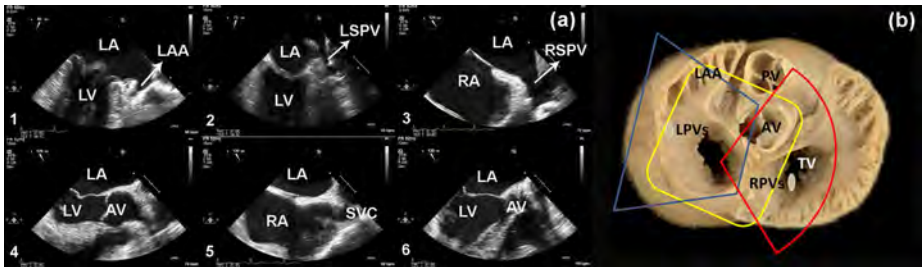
A: 2D transoesophageal echocardiography reference views of the 6-step image acquisition protocol. 1, the mitral commissural view; 2, the superior commissural view including the left upper pulmonary vein; 3, the modified bicaval view including the right upper pulmonary vein; 4, the aortic valve long axis view; 5, the midpoint view between the aortic valve long axis and bicaval views; 6, Further left to the aortic valve long axis view. B: cardiac structures acquired in the 3D datasets of Step 1 (yellow), Step 2 (blue) and Step 3 (red). The grey areas represent the area of the pulmonary vein ostia projected to the cross-section of the anatomical view. AV, aortic valve; LA, left atrium; LAA, left atrial appendage; LPVs, left pulmonary veins; LSPV, left superior pulmonary vein; LV, left ventricle; MV, mitral valve; PV, pulmonary valve; RA, right atrium; RPVs, right pulmonary veins; RSPV, right superior pulmonary vein; SVC, superior vena cava; TV, tricuspid valve. The figure is cited from Ren B et al. *J Interv Card Electrophysiol.* 2013 Jun;37(1):21-6. Permission was obtained.
